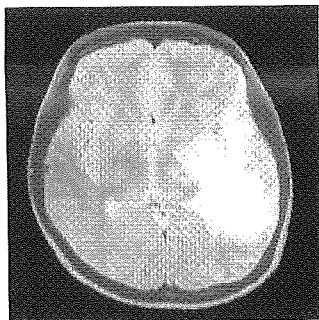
単純ヘルペス脳炎(MRI T<sub>2</sub>強調画像) 23歳女性。健忘と言語障害で発症。左側頭葉に高信号域を認める。
